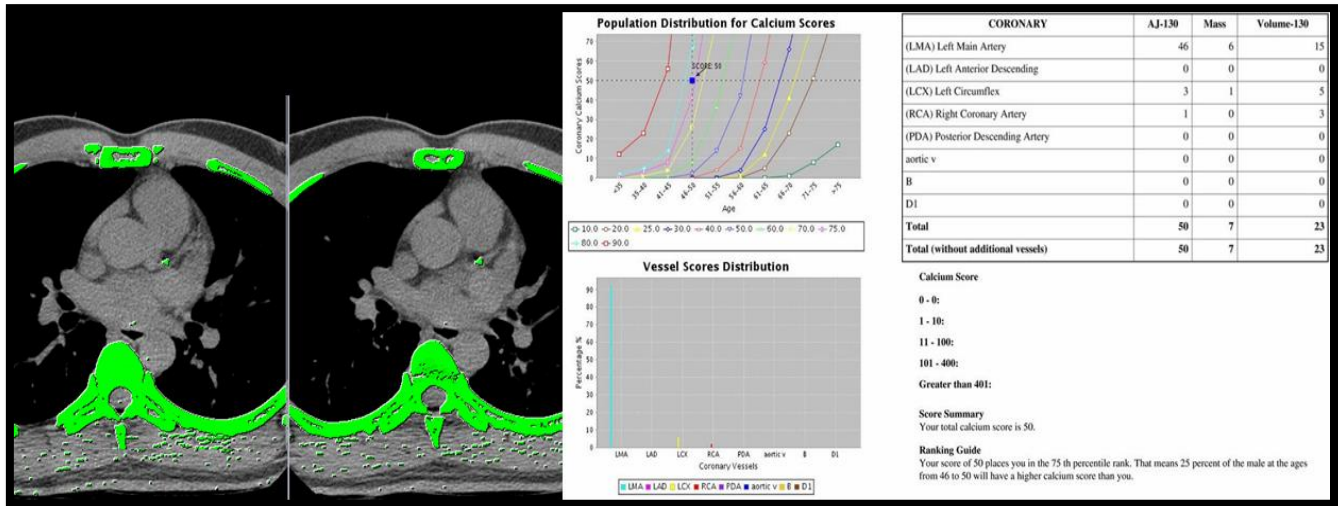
Semiautomated calcium scoring software segments calcific foci (any focus >130HU) on unenhanced CT scans and provides a total score based on Agaston's scoring
